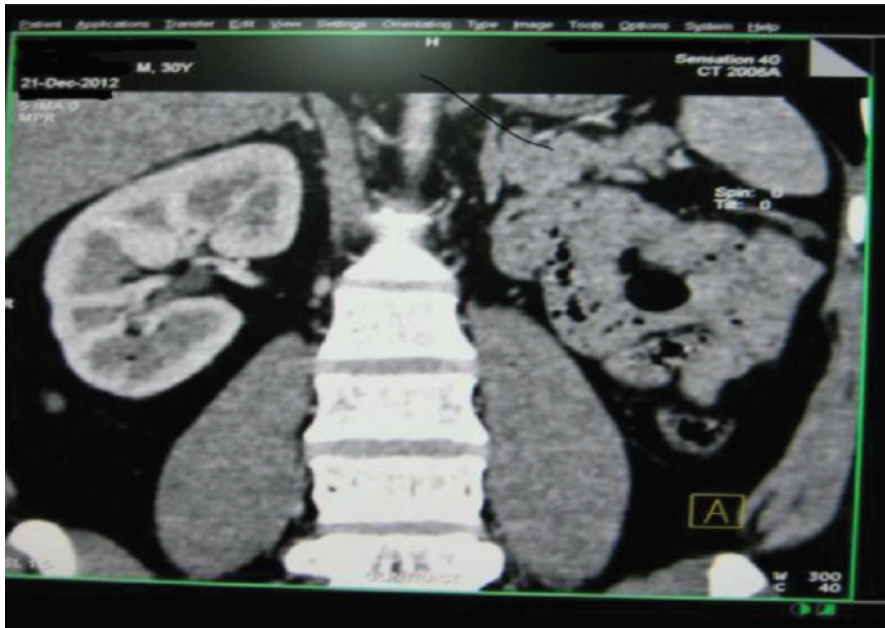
3-D Computed Tomographic Scan showing absent kidney on left [59].
